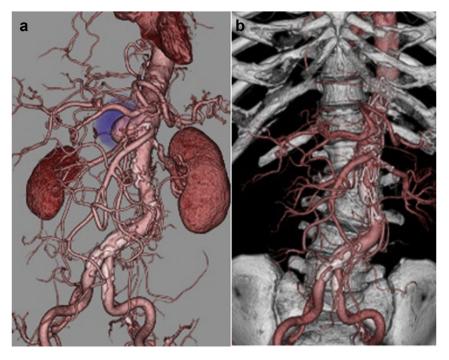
Three-dimensional contrast-enhanced computed tomography showing a 50-mm aortic aneurysm at L1 (a). The enhancement of the aneurysm disappeared after thoracic endovascular aortic repair between Th11 and L3 (b).
